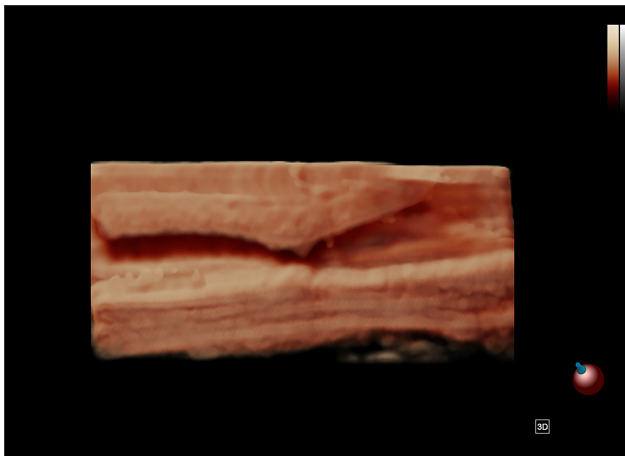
To show the narrowing of the arteriovenous fistulas (AVF) by freehand 3D ultrasound imaging. 3D, three dimensional.
